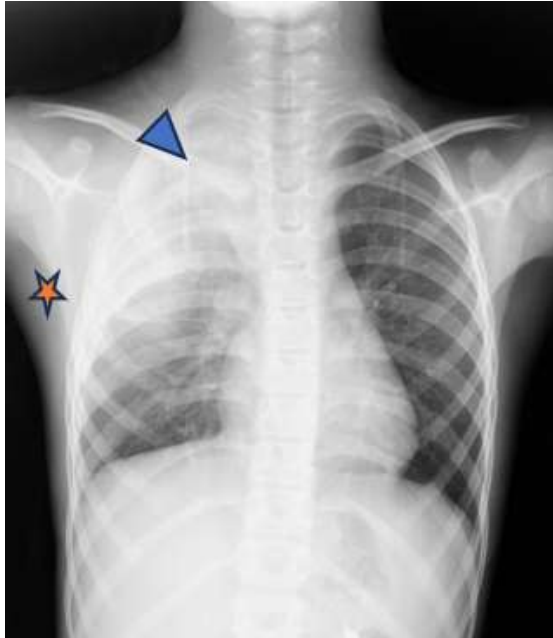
Chest radiograph in frontal view showed a right upper lobe pulmonary opacity (arrowhead) with soft tissue opacities (star).
